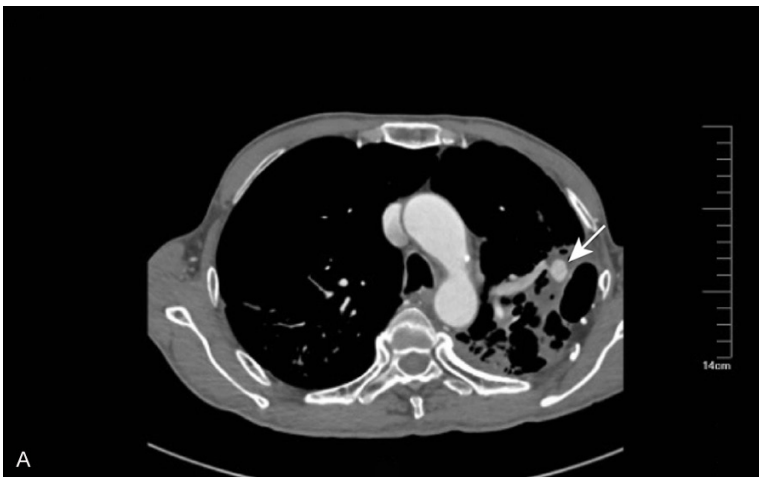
A. High resolution computed tomographical angiography showing peripheral pulmonary artery aneurysm (PPCA) in the cavity of the left upper lobe. B. 3-dependent vascular remodeling revealed a 1.1 cm × 1.7 cm × 1.9 cm (anteroposterior × superoinferior × mediolateral) sized PPCA. White arrow indicated PPCA.
